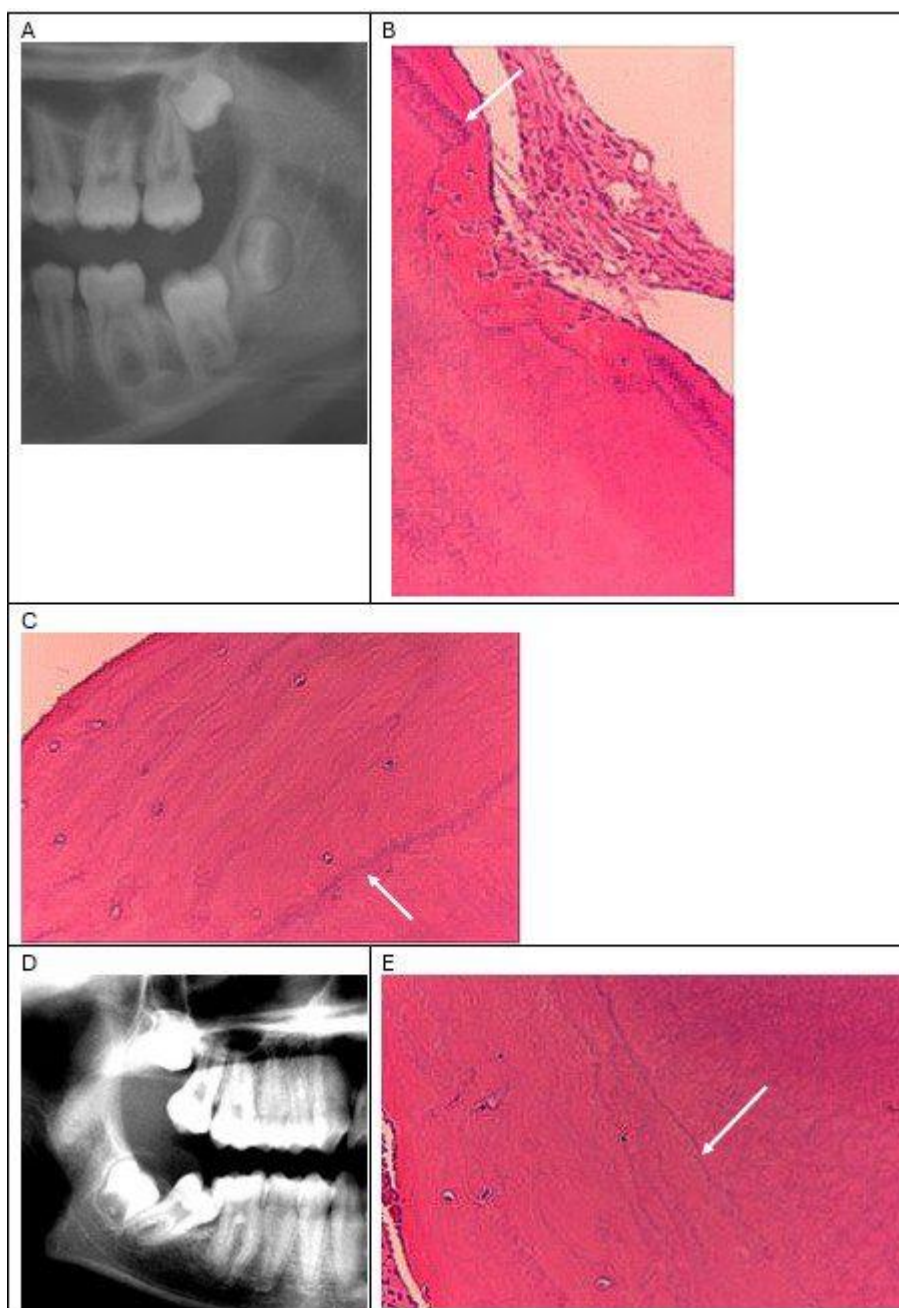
Top (A, B, C): A radiograph and two histochemical sections of a second lower molar from a girl 14 years of age. The radiograph (A) is a section from an OTP demonstrating a second mandibular molar arrested in eruption. The roots of the molar have fully developed. The occlusal plane of the arrested molar is far below the occlusal plane of the first mandibular molar.
